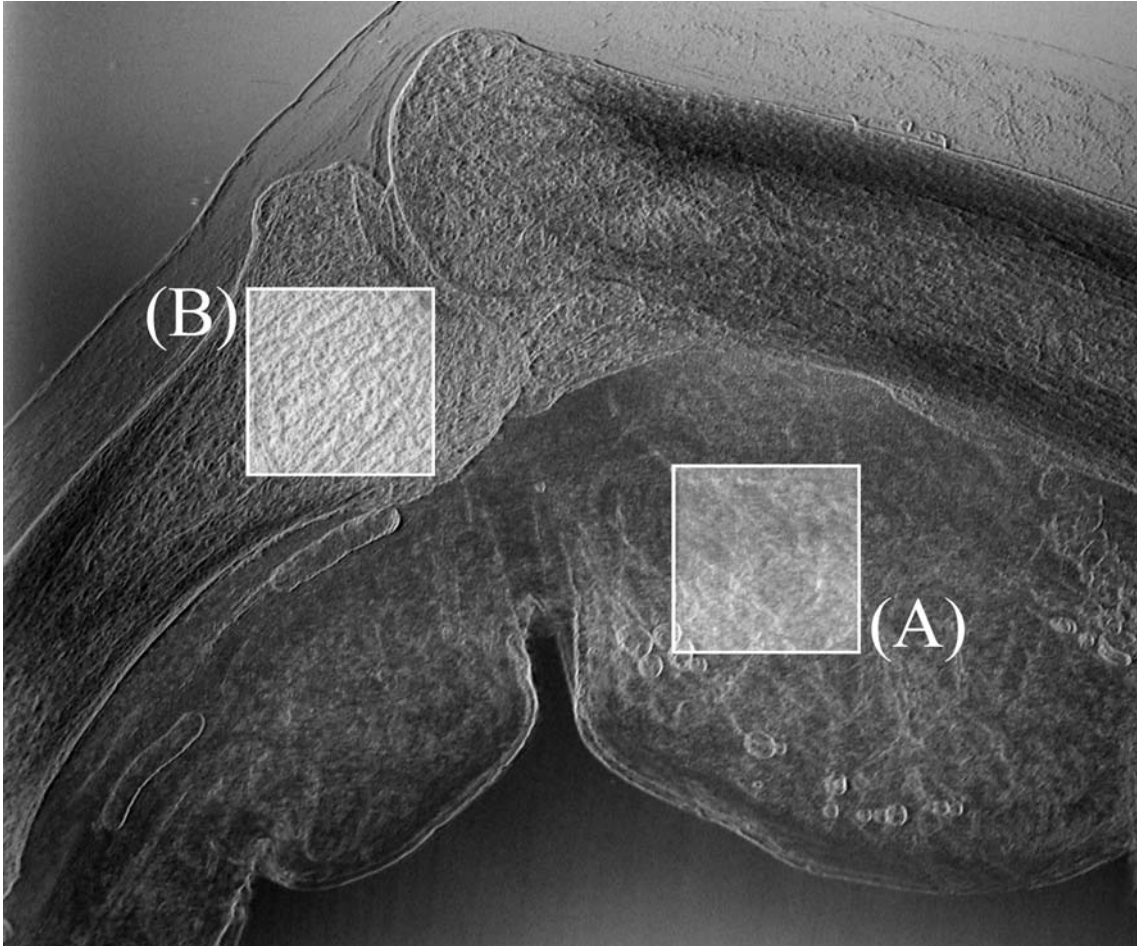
Areas X-rays are incident on for the measurement of rocking curves for soft tissues (A) and bone (B). Areas are both 5 mm square.
